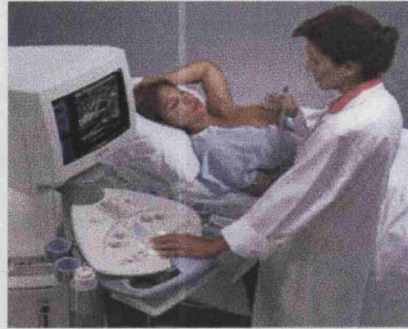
A breast ultrasound scan (website 1).
